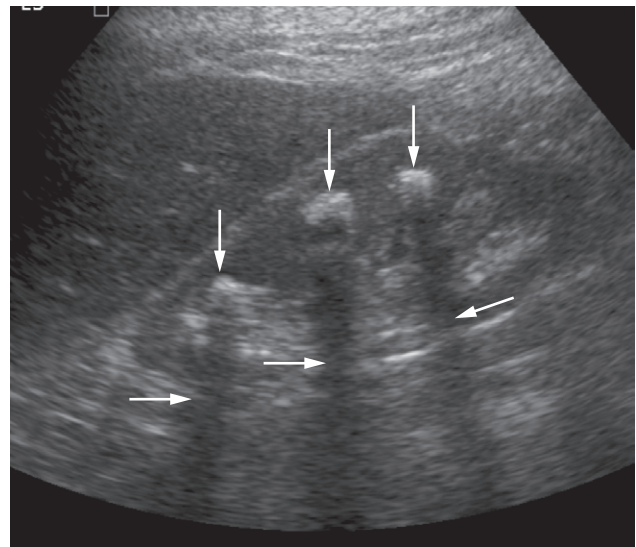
Ultrasound of stones in the right kidney. The stones (vertical arrows) appear as bright echoes. Note the acoustic shadows behind the stones (horizontal arrows).
